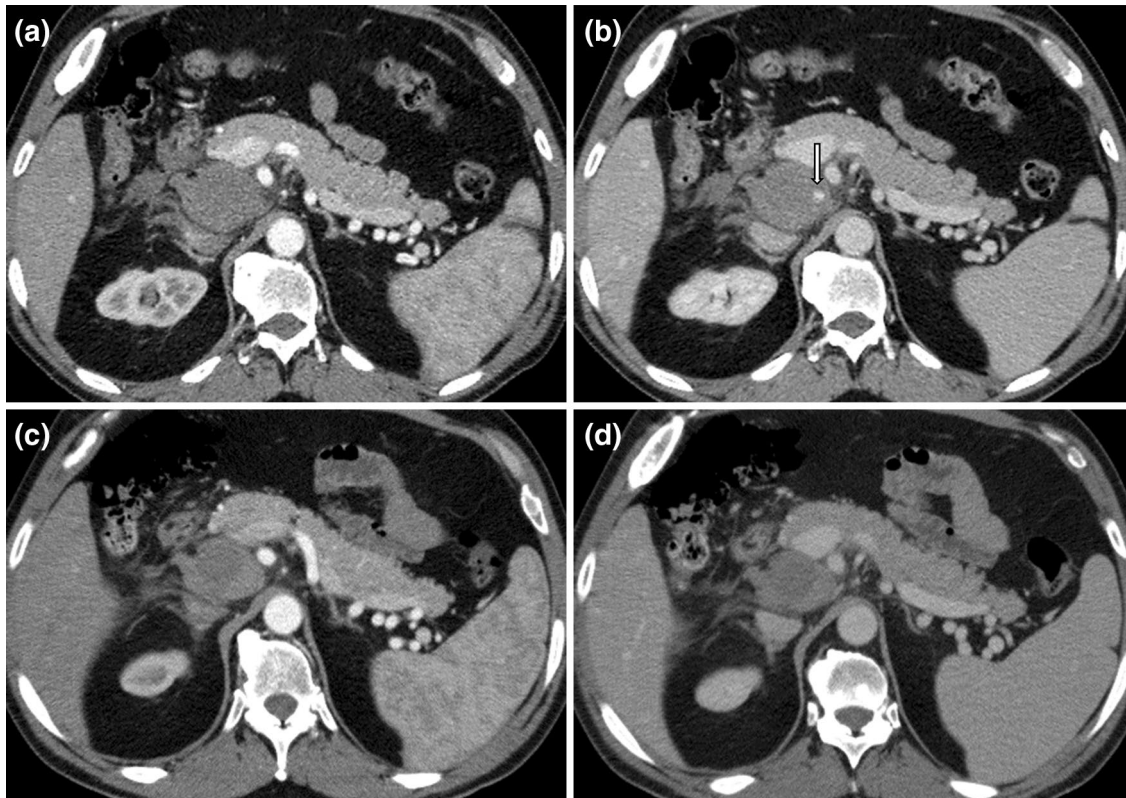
A 51-year-old man suffering severe left flank pain. Arterial phase CT scan shows a circumscribed high-density fluid collection in peri-pancreatic space without signs of medium contrast extravasation (a). CT scan in the portal phase demonstrates a minimum “jet”
